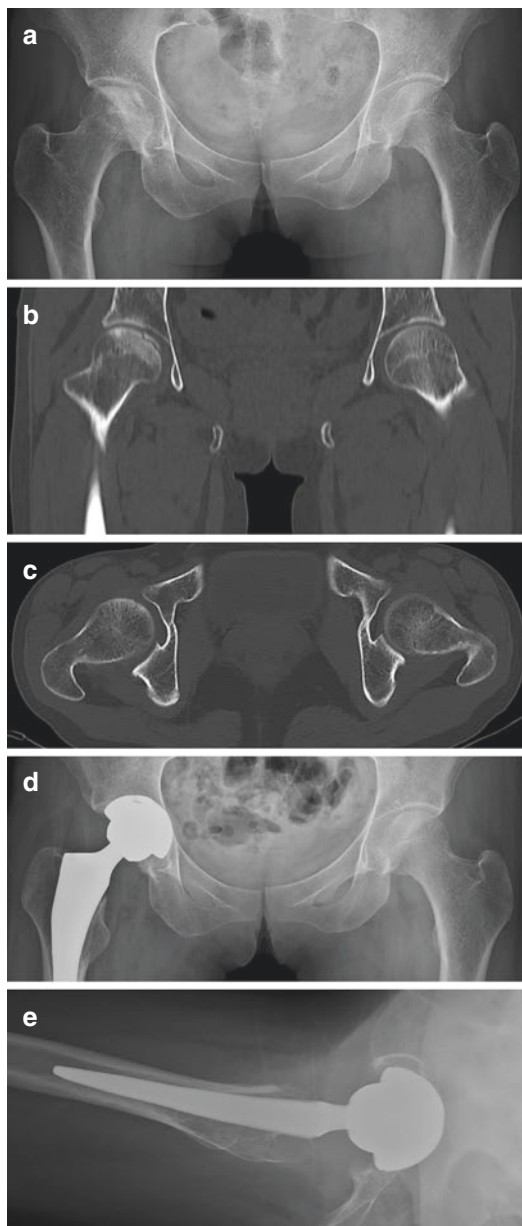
(a–e) A 36-year-old man had osteonecrosis in the right femoral head as seen on his (a) preoperative AP radiograph. (b) The acetabular abduction is 44.6° as measured on the preoperative mid-coronal CT scan. (c) On the preoperative mid-axial CT scan, the acetabular anteversion is 13.7° . (d) The 6-week postoperative AP radiograph shows that the cup abduction is 37.1° . (e) On the lateral radiograph, the cup anteversion is 14.4°
